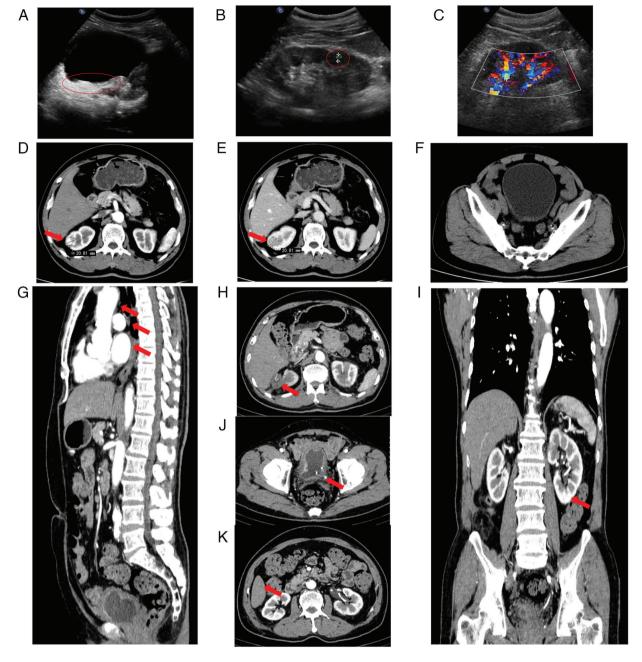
(A) Urinary system color Doppler ultrasound showing bladder wall thickening (circular shape, thickening of the bladder wall). (B) Urinary system color Doppler ultrasound showing increased echogenicity of the right kidney (circular shape, this area of the kidney was more echogenic). (C) Urinary system color Doppler ultrasound showing blood flow signals in the strong echo area of the right kidney (rectangular shape, there were blood flow signals in the normal area and the strong echo area of the right kidney). (D and E) CTU of the urinary system revealing a mass ~2 cm in size at the upper pole of the right kidney, showing a 'fast-in and fast-out' pattern (arrow points to the lesion in the upper pole of the right kidney). (F) CTU of the bladder showing no abnormalities. SPECT showing (G) no mediastinal lymph node metastasis (arrows point to lymph node level), (H) loss of the upper pole of the right kidney and a small amount of exudate after laparoscopic partial nephrectomy (arrow points to the right partial nephrectomy area), (I) no left renal metastasis (arrow points to the lower pole of the left kidney) and (J) the postoperative bladder showing diffuse bladder wall thickening. The high-density shadow in the bladder indicates a left ureteral stent (placed after transurethral resection of bladder tumors to prevent left ureteral stenosis) (arrow points to the high-density shadow). (K) SPECT showing no liver metastasis (arrow points to the liver). CTU, computed tomography urography; SPECT, single-photon emission computed tomography.
